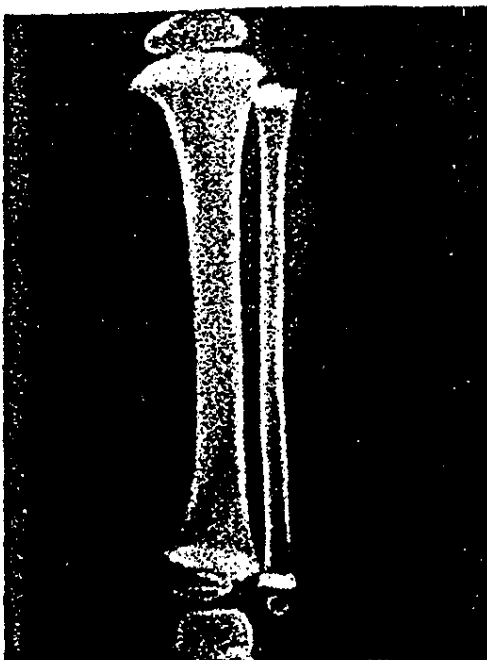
Dense "lead lines" are seen in these x-rays of the upper and lower tibial and fibular metaphyses of a child with lead intoxication.
